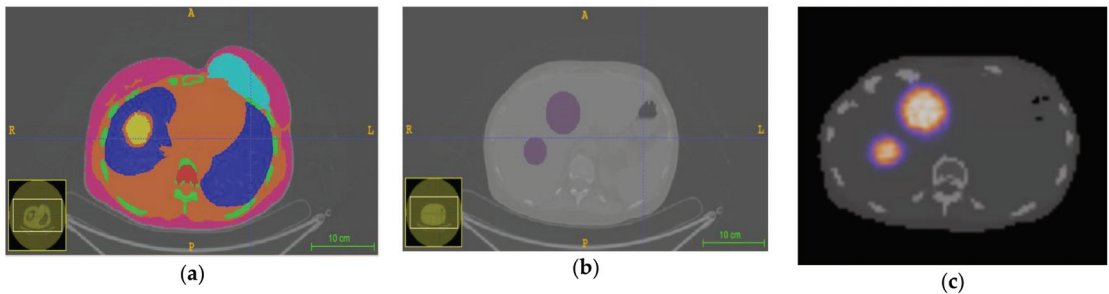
Three transverse slices of different images used in the SR case: (a) contoured CT (in this slice all the contoured regions are visible), (b) activity map and (c) SPECT superimposed on the coregistered CT. Activity is just in the spheres (MS and BS are visible in (b,c), while SS is located on another transversal plane).
